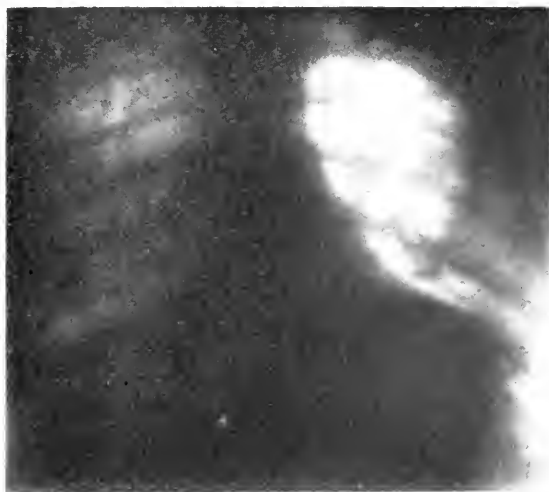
Henry S. Roentgenogram taken June 13, 1916, on discharge.
